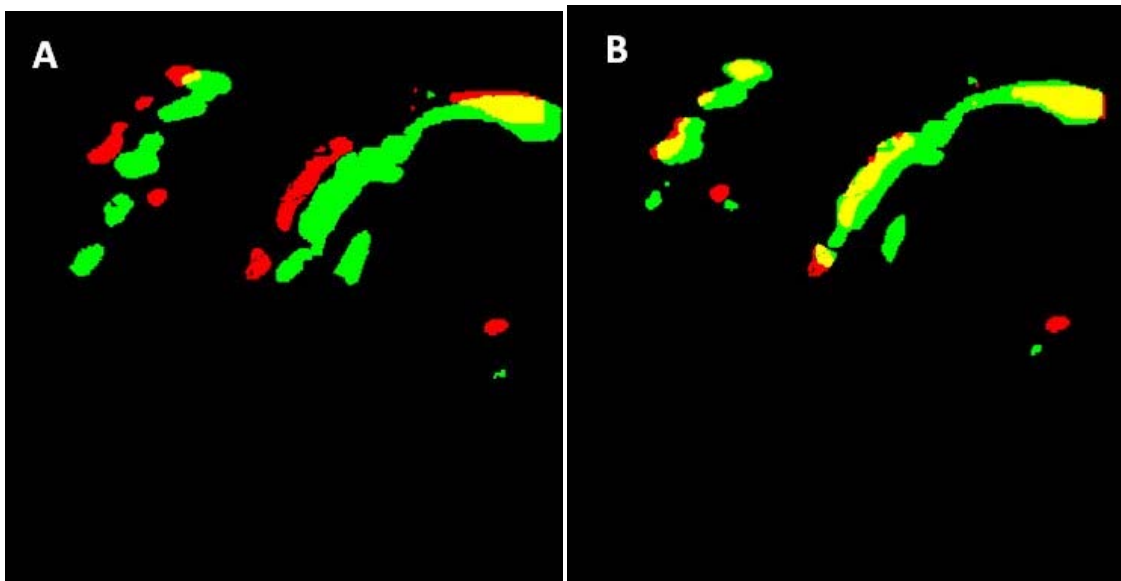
Unregistered pair (A) and registered pair (B) in a slice of 3D Doppler color image volumes with grayscale portion blacked out. Red was the color of blood flow under moderate breast compression; green under relaxed compression and yellow was the overlap region. Notice the increase in flow with relaxation and also increase in yellow region with registration. The registration was performed on the grayscale portion of the image volume (not shown here). Refer Figure 3.5 and Figure 3.6.
